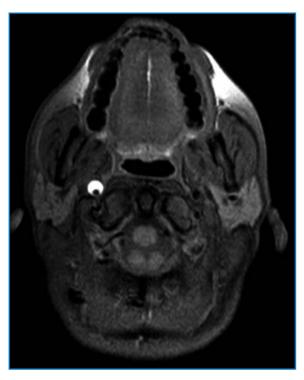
MR image shows the parietal hematoma characteristic of a right carotid dissection
